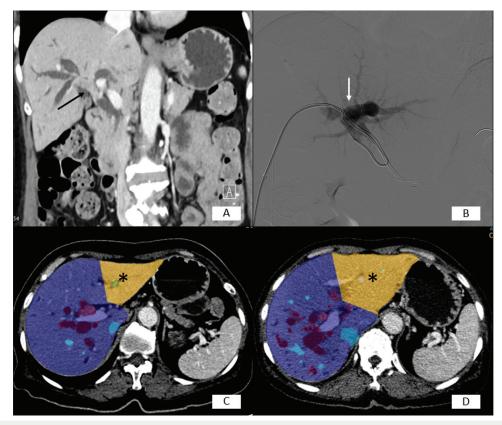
A 65-year-old female patient with perihilar type cholangiocarcinoma (CCA), Bismuth-Corlette type IIIA, planned for extended right hepatectomy. (A) CT scan upper abdomen shows extension of perihilar CCA (arrow). (B) Portogram after right PVE shows occlusion of right portal vein with patent left portal vein (arrow). (C) CT volumetric program contouring lateral segment of left hepatic lobe as FLR (*) for calculated volume. (D) CT volumetric program after right PVE 30 days, contouring lateral segment of left hepatic lobe (*) shows hypertrophy of FLR (FLR increase 77.1%).
